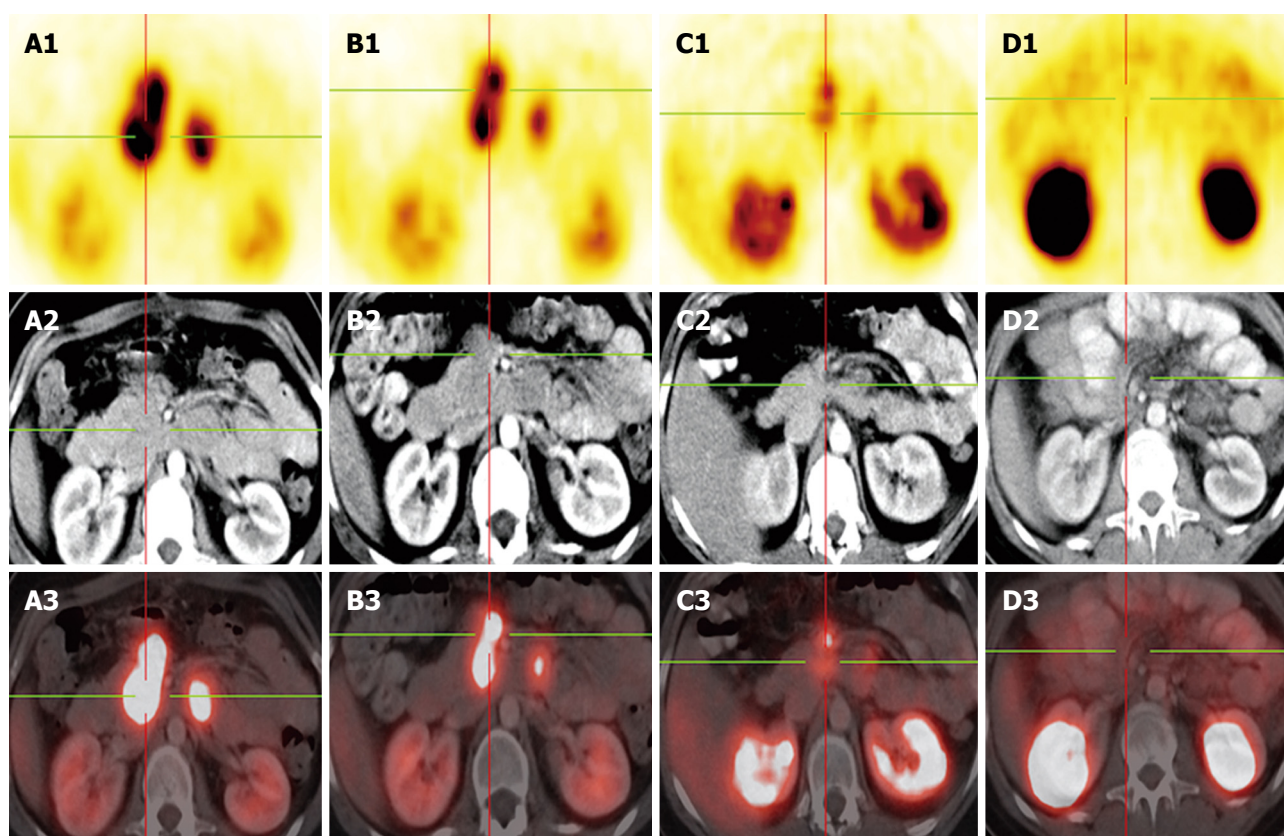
Gallium-68 DOTA-NOC PET-CT in the follow up. A: Octreotide scan prior to PRRT-1, Gallium-68 DOTA NOC PET-CT and prior operation, showing multiple paraaortal lymph nodes next to the pancreas head; B: 3 mo after PRRT-1; C: 5 mo after PRRT-2 showing consistently decreasing mesenterial lymph nodes metastases with a decreasing SUV; D: Octreotide scan as follow up 18 mo after operation-complete remission.
